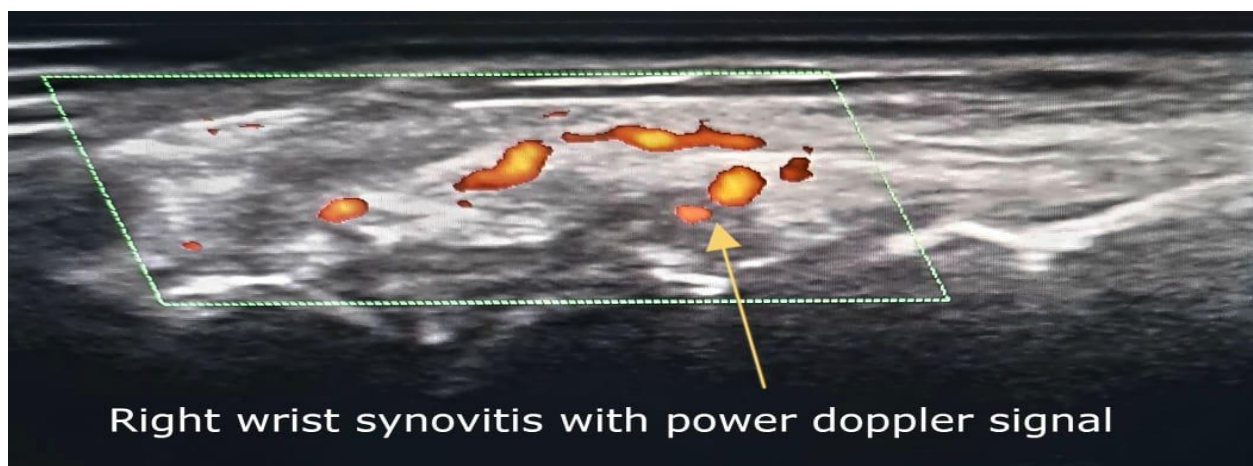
Power Doppler musculoskeletal ultrasound of the long axis of the dorsal aspect of the right wrist of the same patient showing hyper-vascularization with denoting synovial inflammation with grade 2 power Doppler signal.
